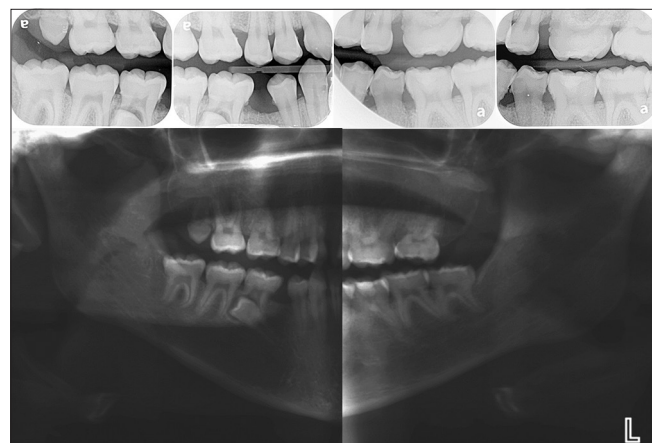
Bitewing and panorex radiographs. Panorex image is tailored from two different images from each side (see rationale in text). Bitewings and panorex show impacted #29 and resorption of #30 roots and impacted conical #1. Impacted #17 and #32. The left side permanent molars appear larger in size than the right permanent molars (radiographically the molars appear rotated, but clinically they are within normal limits)
